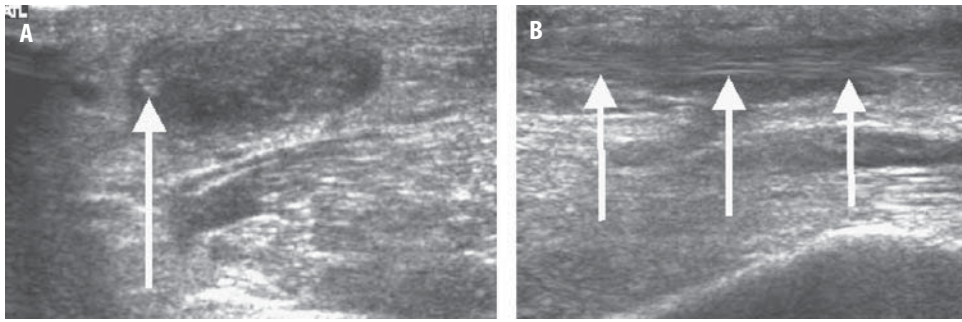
Transverse (A) and longitudinal (B) ultrasonographic images of a full thickness tear of the Achilles tendon, demonstrating an intact echogenic plantaris tendon (solid arrows).
